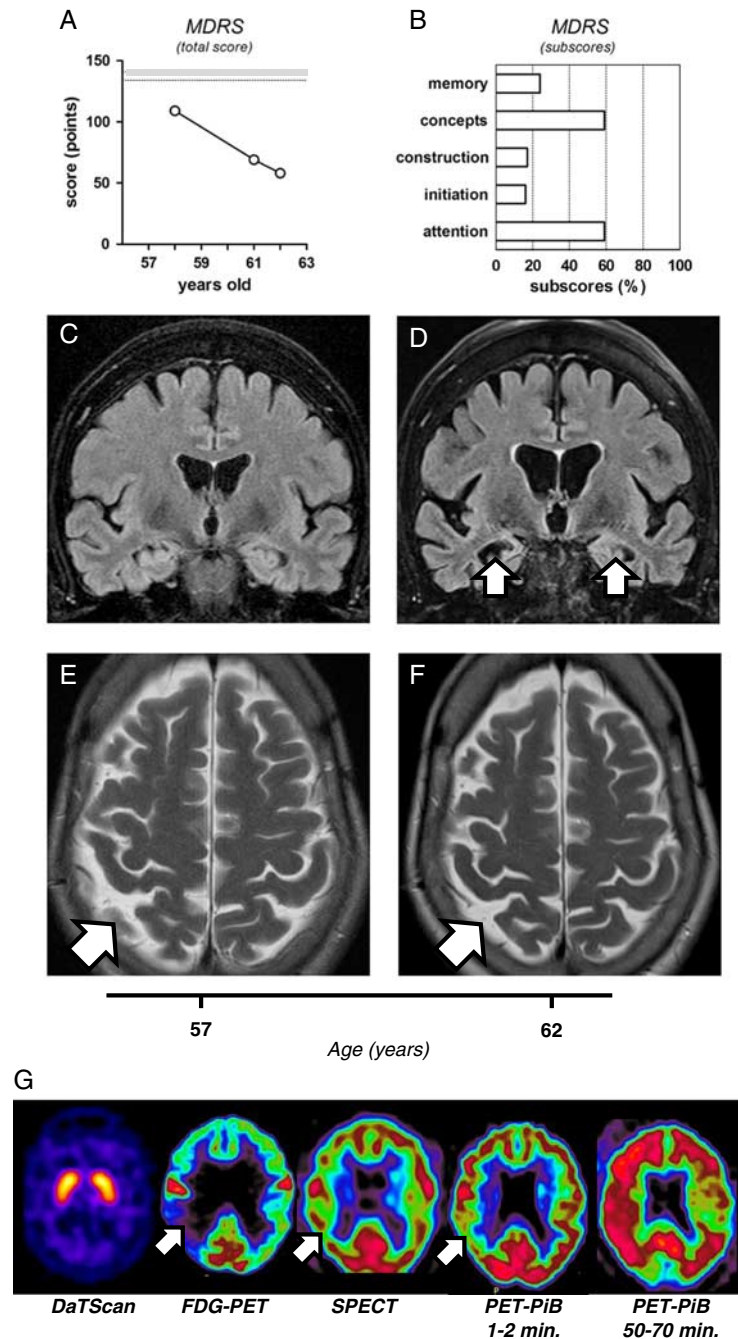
Neurocognitive and brain structural and metabolic assessment of the reported patient. A, Changes in the total score of Mattis dementia rating scale (MDRS), indicating progressive cognitive decline (109/144, 69/144, and 58/144, at the age of 58, 61, and 62, respectively). Shaded range indicated on the panel represents a 25 to 75 percentile interval, previously established for the population younger than 70 years old. B, Specific MDRS subscores collected at the age of 62, and expressed as a percentage of the maximal possible value for each subscore. C-D, The coronal FLAIR imaging, demonstrating a clear progression of the hippocampal atrophy (white arrows) within 5 years of follow-up, from the age of 57 (C) to 62 (D). Note the right hemispheric dominance of the hippocampal atrophy and consecutive dilation of the temporal horns of the lateral ventricles. E-F, The axial T2 shows a mild parietal atrophy (white arrows), again with right hemispheric predominance, which only slowly progressed between the age to 57 (E) and 62 (F). Note the absence of microvascular white matter lesions. G, Metabolic neuroimaging. DaTScan imaging shows normal uptake of the tracer in the caudate and putamen. FDG-PET indicates global decrease in cerebral metabolism, particularly severe in the right temporo-parietal region (white arrow). SPECT reveals generalized hypoperfusion, slightly predominant on the right side (white arrow). Positron-emission tomography with Pittsburgh compound-B (PET-PiB) shows decreased tracer activity after 1 to 2 minutes, especially in the right temporo-parietal region (white arrow), and massive and widespread retention of PiB after 50 to 70 minutes, again with right predominance.
